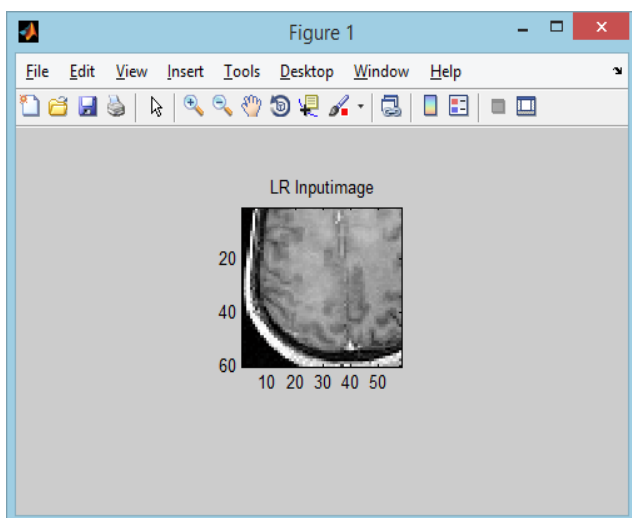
MRI Scanned Image
